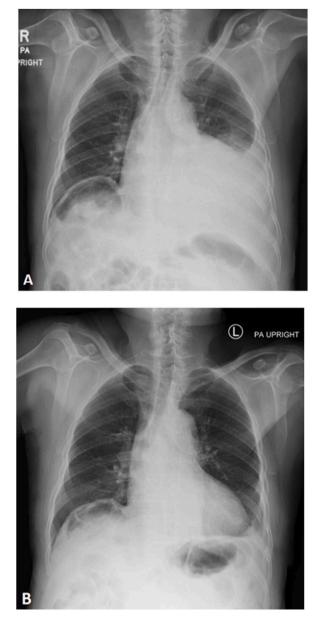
Chest radiographs. (A) Before treatment. (B) After 4 weeks of treatment.
